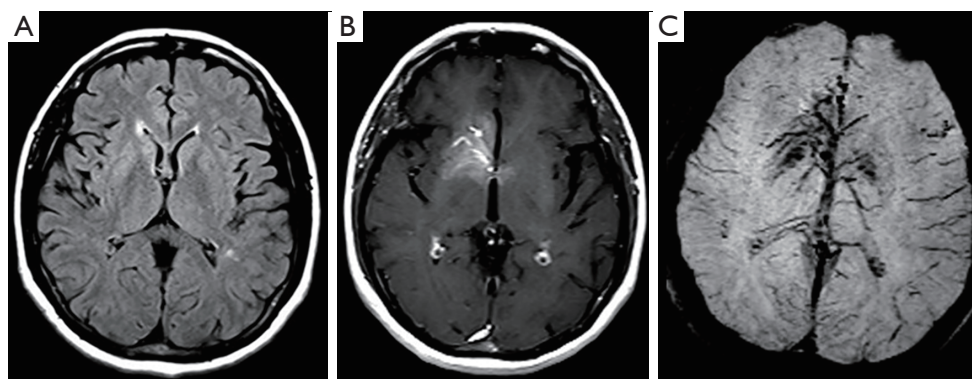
(A) Axial FLAIR image demonstrates no abnormality; (B) post-contrast axial T1W image shows DVA with classical caput medusae appearance in the right basal ganglia. In addition, there is contrast enhancement in the basal ganglia around DVA; (C) SWI shows DVA which is invisible on conventional MR sequences without requiring contrast-media.
